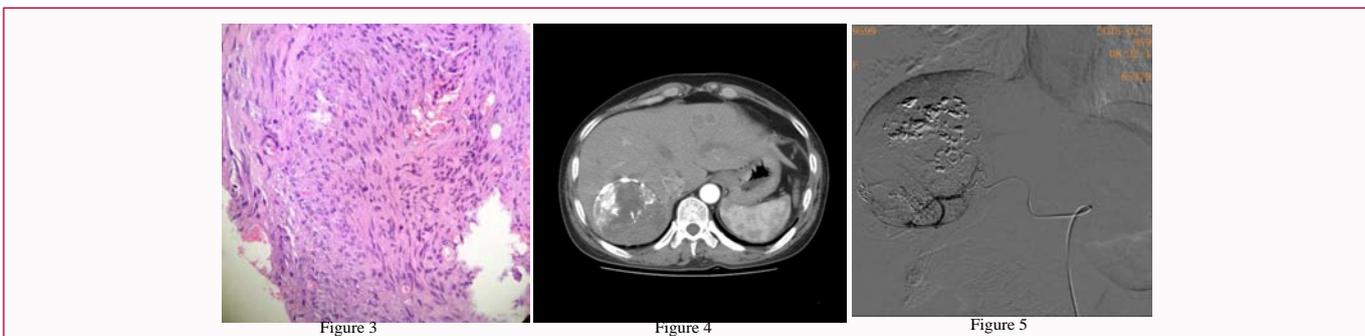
The pathology of the lesion in liver showed gastrointestinal stromal tumor. The enhanced CT reexamination on January 28, 2015 showed that the maximum diameter of the tumor was 8.6 cm × 8.0 cm, which was slightly smaller than before (Figure 4), so the second TACE was performed (Figure 5).
